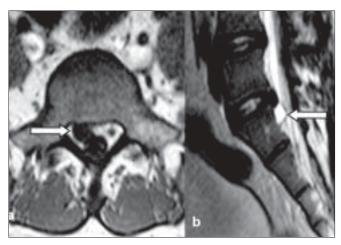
MR imaging of a 26-year-old man showing (a) Axial non contrast T1W image of the lumbosacral spine showing a ventrolaterally placed right-sided extradural lesion (arrow) at the L5S1 disc space level.
